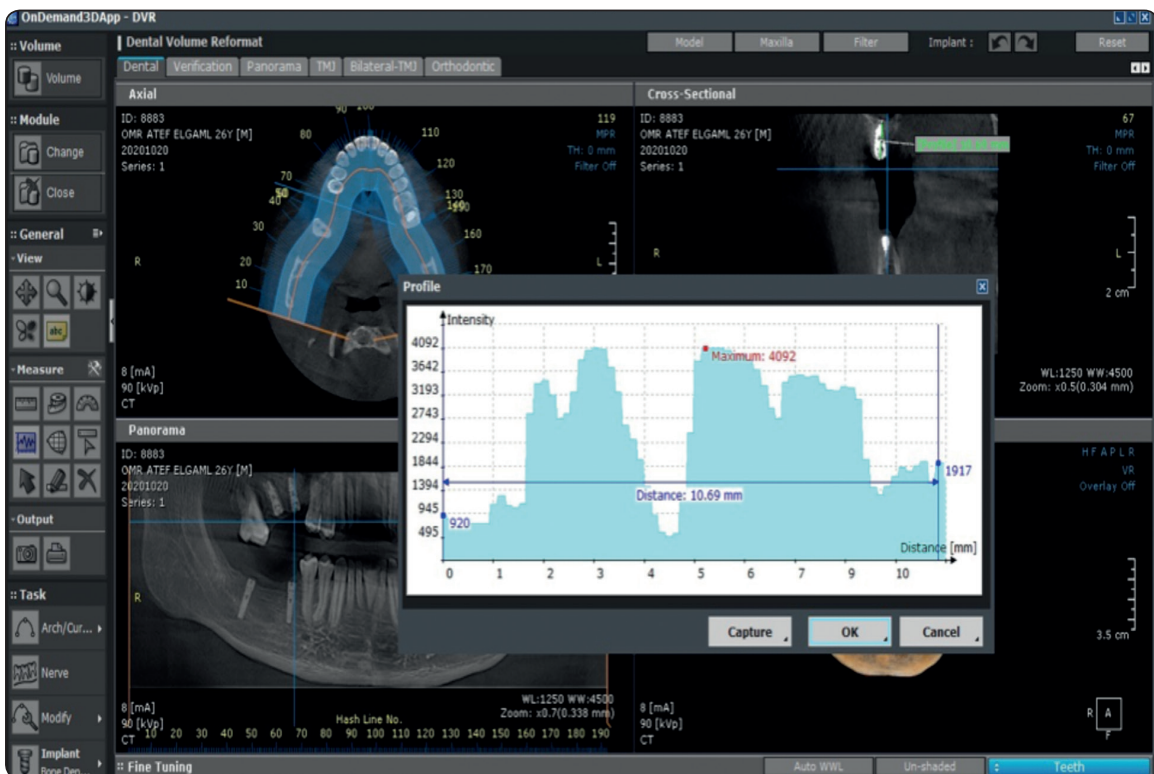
Showing 6 months postoperative CBCT, measuring the height of endo sinus bone gain.
